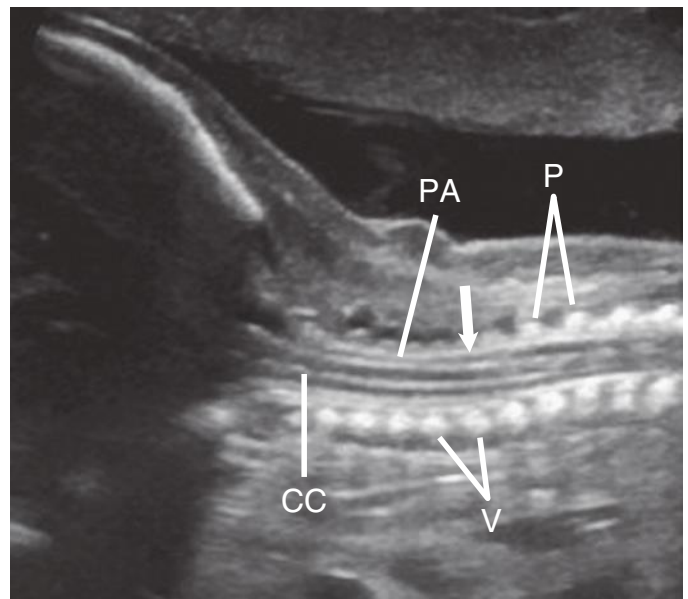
Longitudinal sonogram at the craniocervical junction demonstrating the cervical cord (CC). (Arrow), dura; P, posterior arch ossification centers; PA, pia-arachnoid; V, vertebral body ossification centers.
